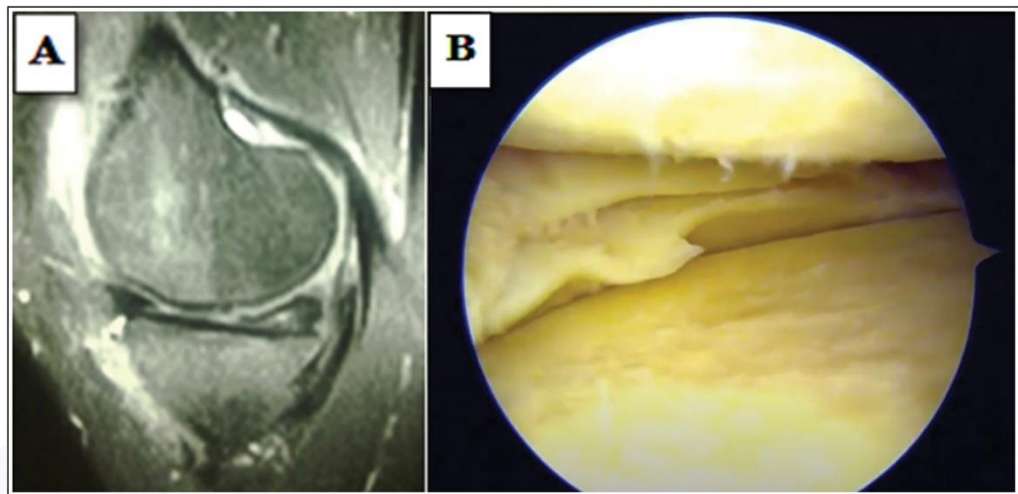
True positive MRI result. (a) An MRI scan revealed a horizontal tear in the posterior horn of the medial meniscus. (b) The rupture was confirmed by arthroscopy.
